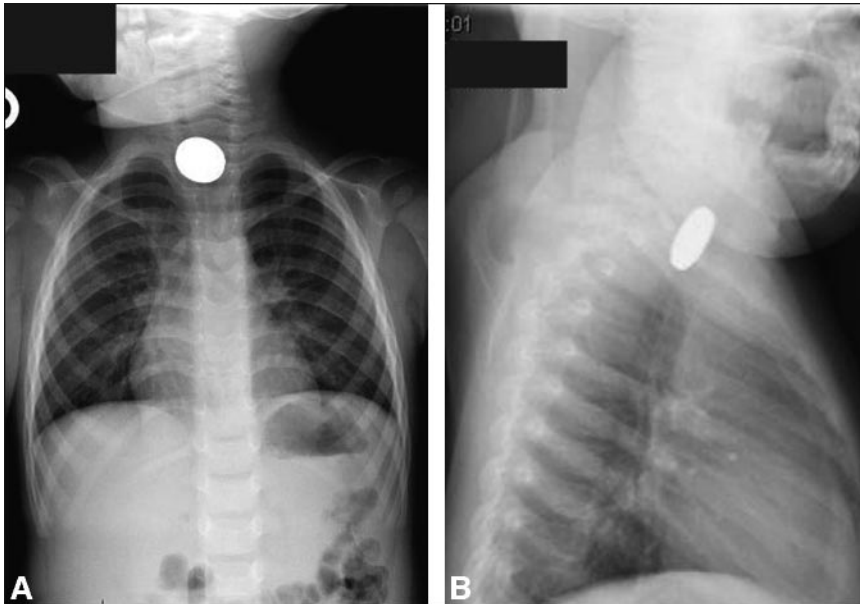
A. Esophageal coin projects *en face* on a posteroanterior chest radiograph. B. The same esophageal coin is seen from the side on a lateral chest radiograph.
